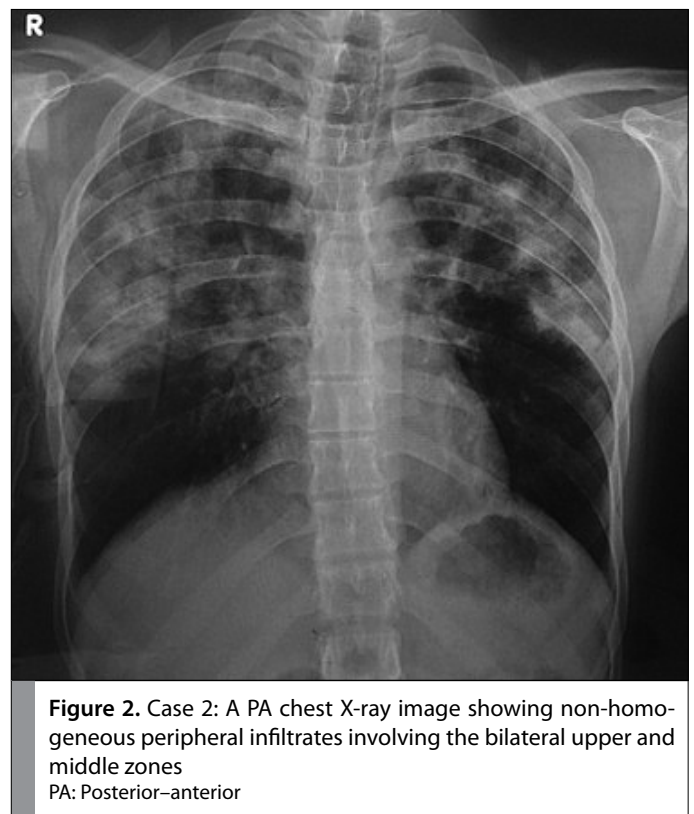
Case 2: A PA chest X-ray image showing non-homogeneous peripheral infiltrates involving the bilateral upper and middle zones
